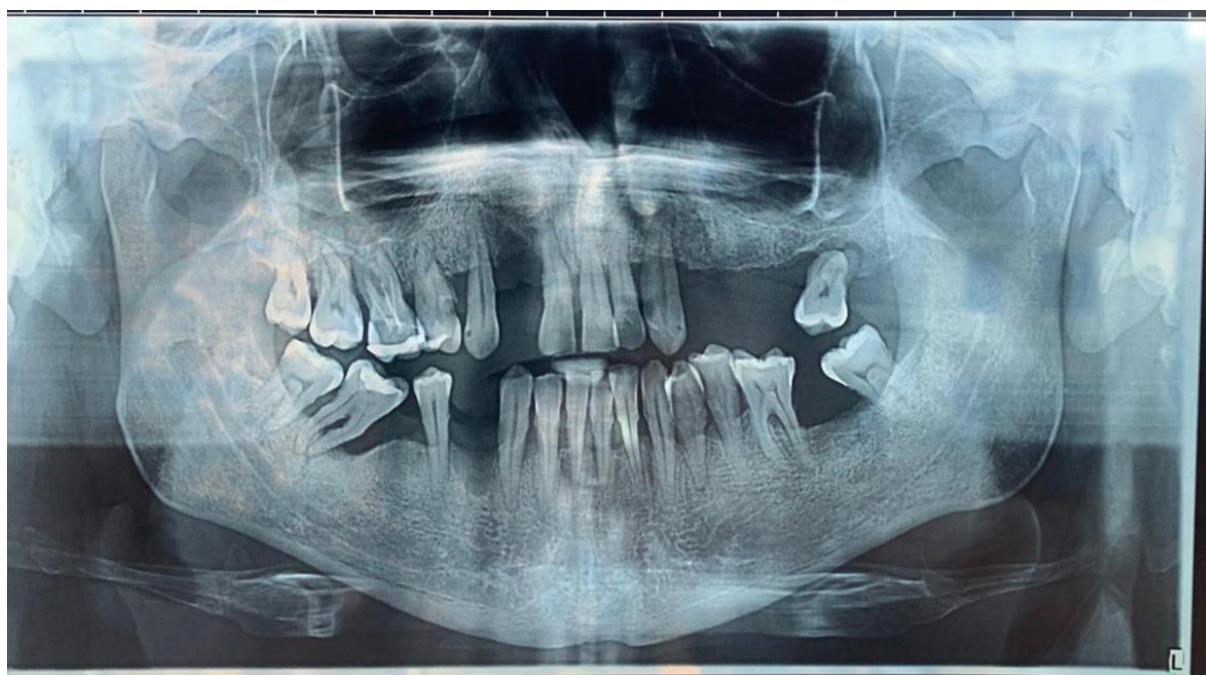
Initial orthopantomography
